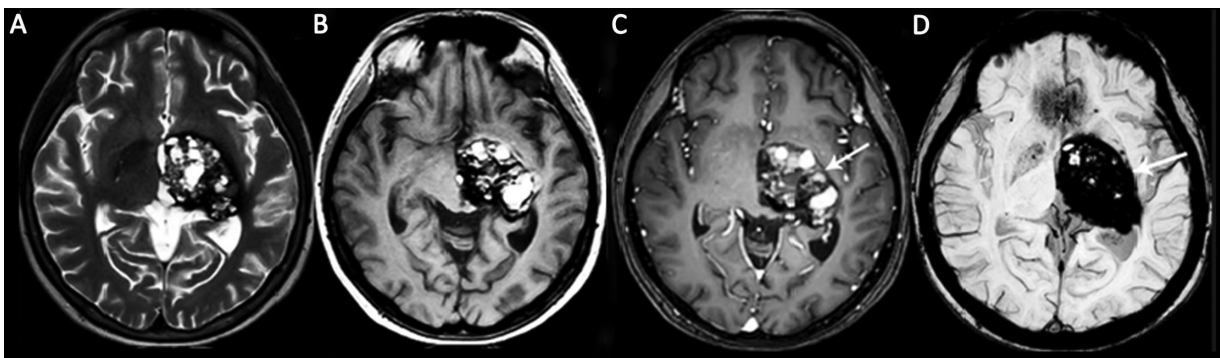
A left thalamus giant cavernous malformation (CM) in a 25-year-old female patient with a headache and progressive right-sided weakness. (A) Axial T2-weighted (T2W) and (B) T1W magnetic resonance (MR) images show a complex-appearing mass with heterogeneous signals and cystic areas. (C) Contrast-enhanced T1-weighted image (TIWI) shows heterogeneous internal enhancement (arrow). (D) Susceptibility-weighted imaging (SWI) shows an intense inhomogeneous blooming artifact (arrow).
